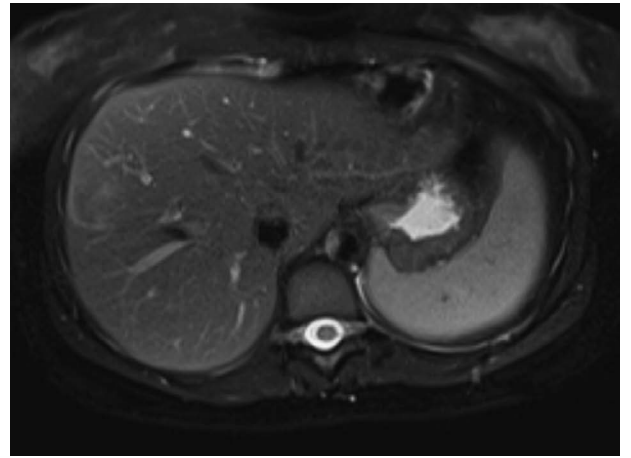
Liver. MRI. T2 weighted. Single shot. Fat suppression. Axial plane.
